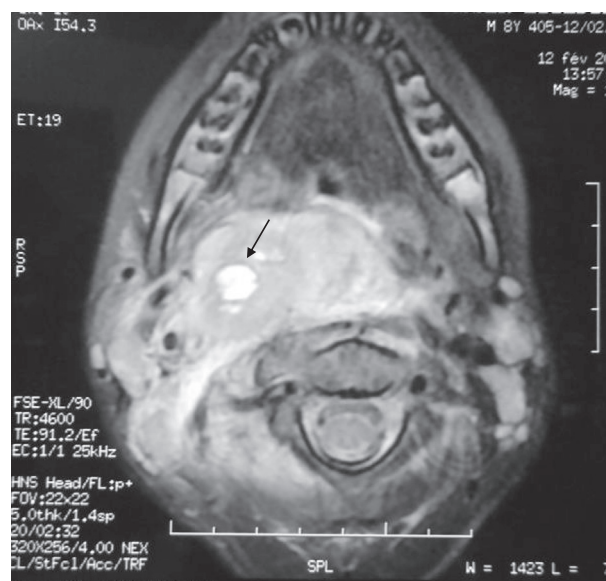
T2-weighted MRI showing tumoral pharyngeal process associated to necrotic retropharyngeal lymph nodes (arrow).
